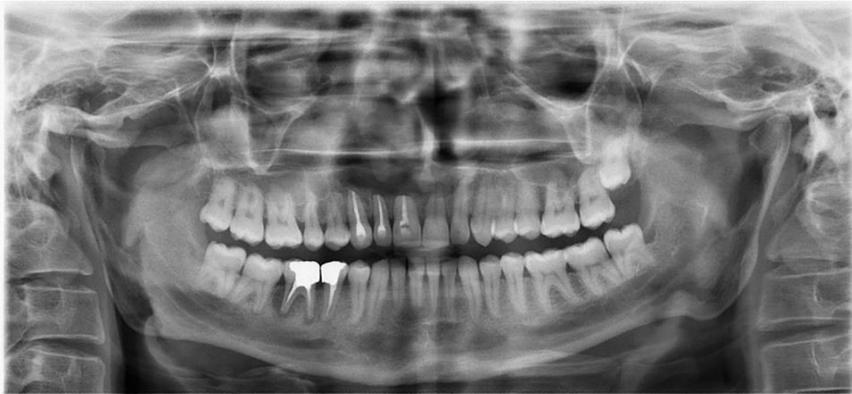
Post operative xray after 10 months from enucleation.
